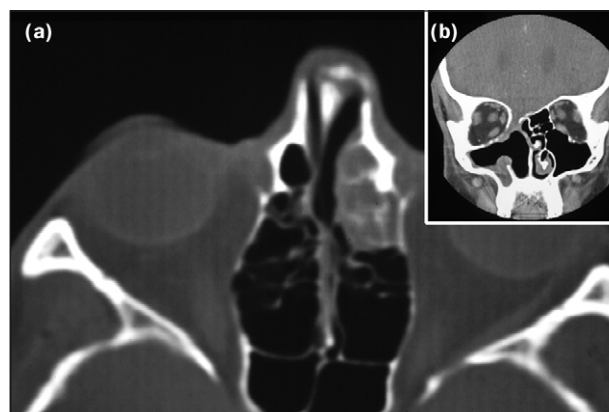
Preoperative and postoperative CT scan of a patient with ENB. (a) preoperative CT scan shows a non-specific opacification of the anterior ethmoid cells. In this horizontal imaging, the lesion appears of limited extension and does not invade the orbit. Note that the lesion is unilateral, a sign that suggests a malignant process. (b) Coronal CT scan after craniofacial resection. The entire ethmoid labyrinth on the involved side has been resected, including the ethmoid roof. The upper part of the adjacent septum has also been removed. In this case, the contralateral cribriform plate was preserved, allowing for residual olfactory function.
